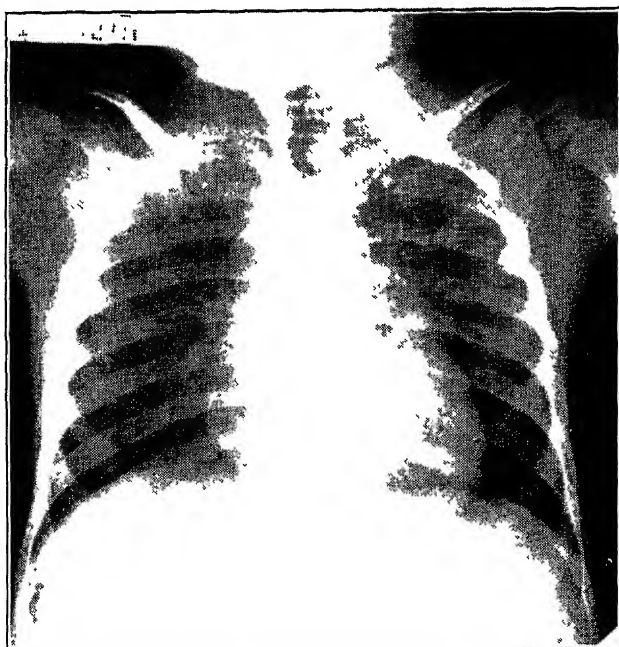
Same case as Fig. 3, roentgenogram taken 4 years later. Shows calcification in area of left upper as well as right hilus region. (Mitchell and Nelson, Ohio State M. J.)
